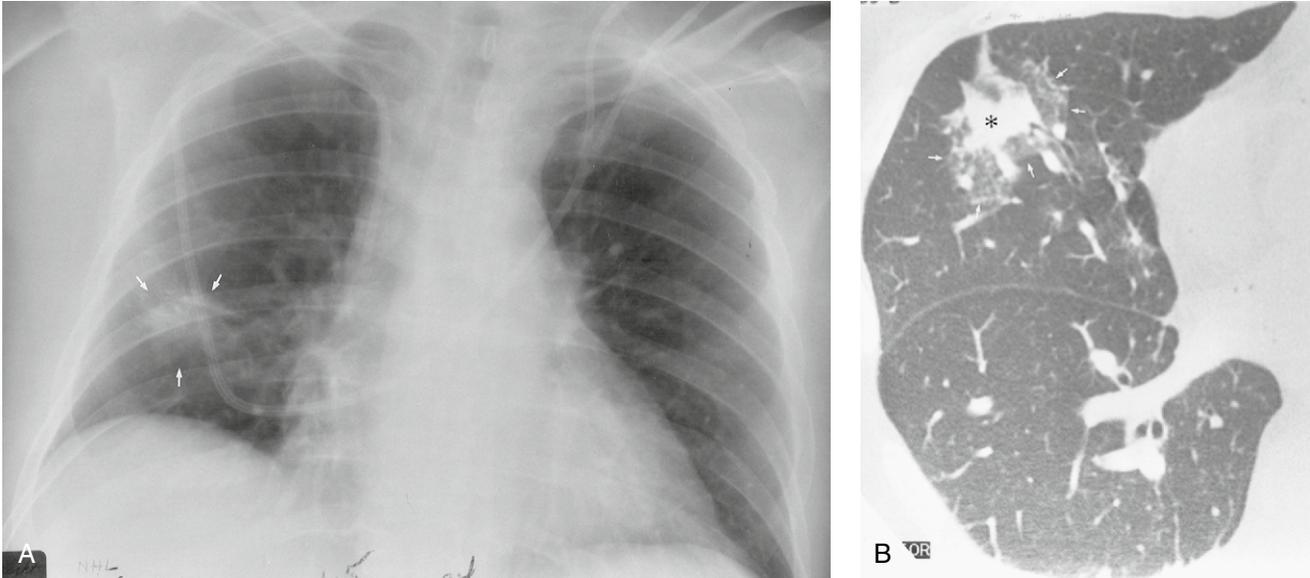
Invasive pulmonary aspergillosis in a 47-year-old man with low-grade stage IV non-Hodgkin lymphoma treated with bone marrow transplantation and chemotherapy. (A) AP bedside chest radiograph demonstrates focal, poorly margined airspace opacity (arrows) in the right mid lung. A central venous catheter is also present. (B) High-resolution chest CT image (lung window) shows an irregular, 2 cm nodular opacity (asterisk) in the right upper lobe, surrounded by ground-glass attenuation, “halo” sign (arrows). Autopsy revealed invasive pulmonary aspergillosis with multiorgan dissemination.
